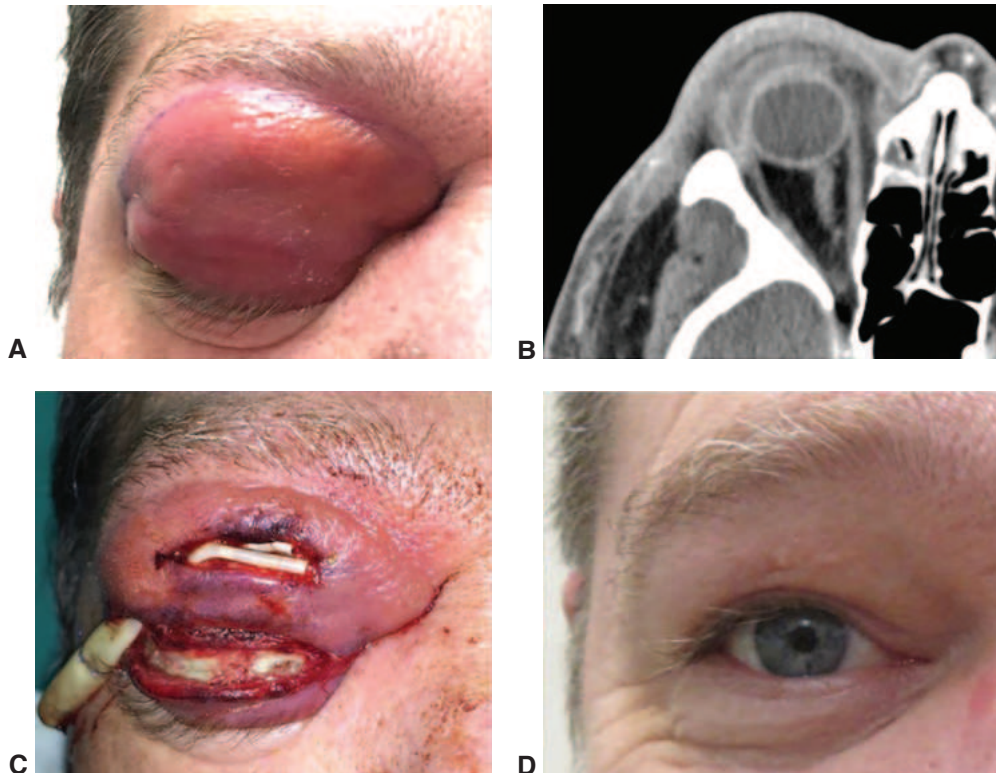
Necrotizing fasciitis. A, A patient with marked erythema and induration with early bullae formation. B, Axial computed tomography (CT) imaging study shows the spread of infection along preseptal fascial planes. C, Debrided tissues and drain, photographed immediately after surgery. D, Patient after extensive debridement and systemic antibiotic therapy. (Courtesy of Julian D. Perry, MD, and Catherine J. Hwang, MD.)
